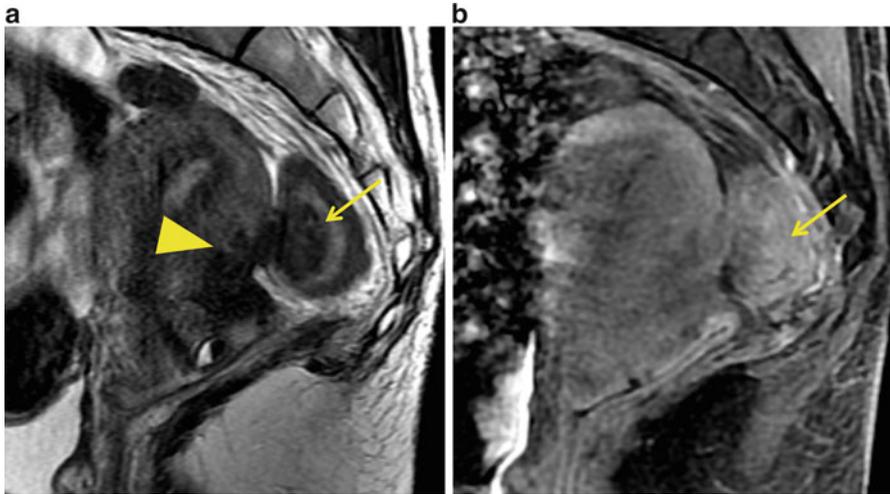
A 30-year-old woman with deep pelvic endometriosis infiltrating the rectosigmoid. Rectosigmoid involvement shows hypointense fan-shaped configuration on sagittal T2-weighted image (a) and contrast enhancement on enhanced T1-weighted image (arrow). An irregular hypointensity area at posterior serosal surface of uterus is also found (arrowhead)
